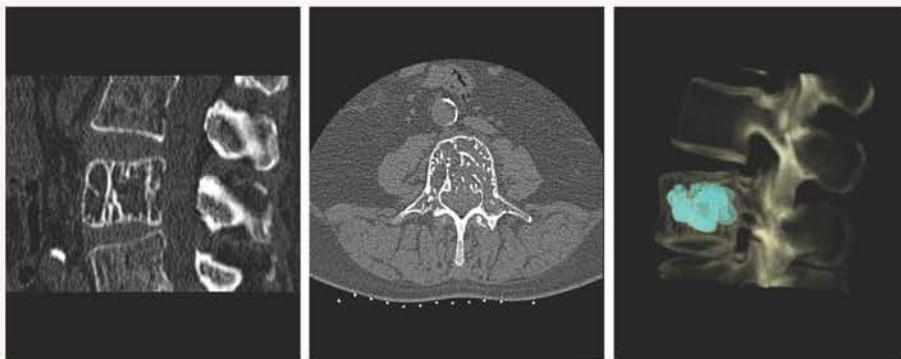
Painful pending vertebral collapse due to an aggressive haemangioma treated with PVP. From left to right: sagittal and axial CT-reconstruction both showing the specific trabecular destruction leading to a typical cement filling pattern as seen at a 3D CT-reconstruction (far right).
